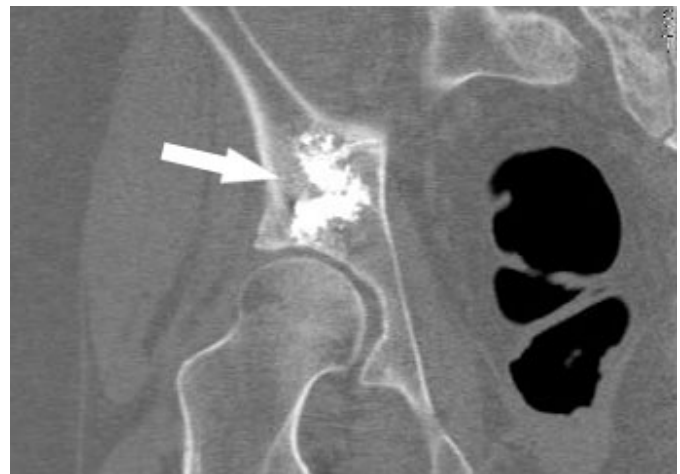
Post-procedure CT scan after augmentation of right acetabulum showing satisfactory placement of cement.
